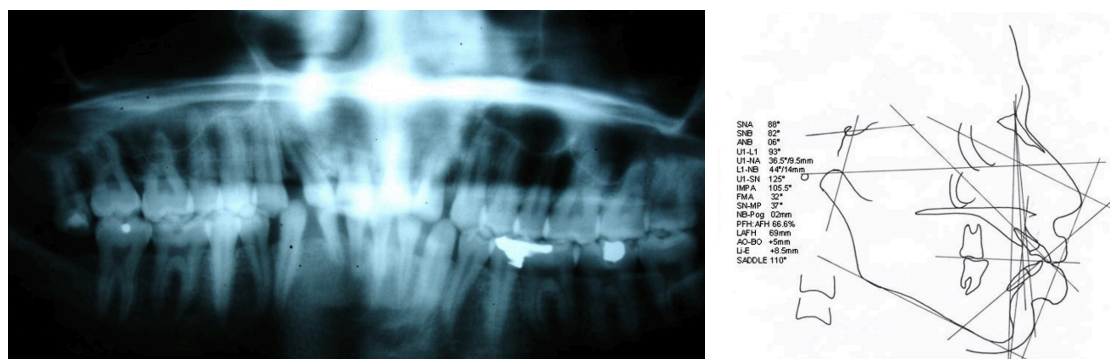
Panoramic radiograph and Cephalometric analysis.
